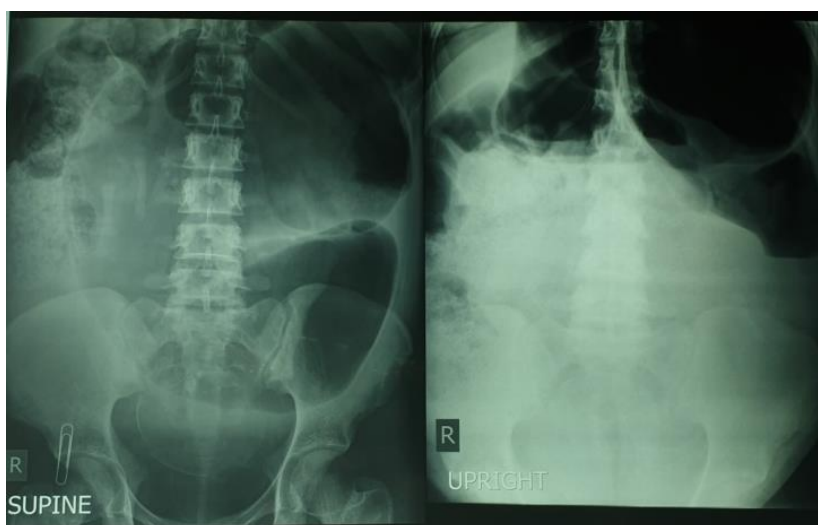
Abdominal X-ray image (lying / standing) showing fluid-air surface of dilated colon with inverted -U view.
